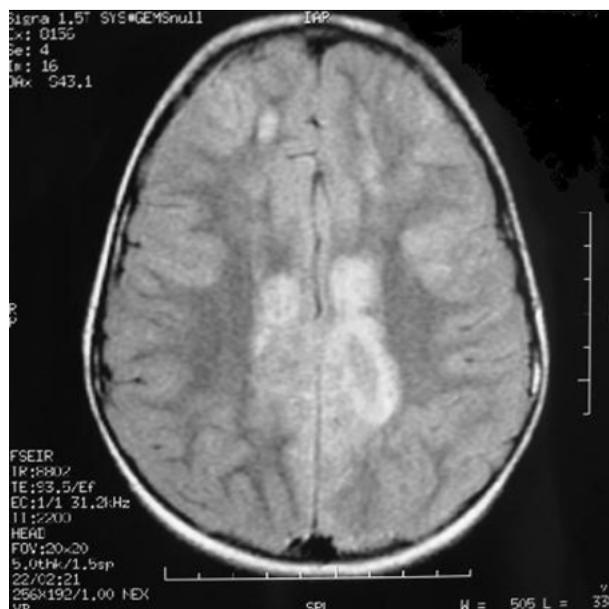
Cranial magnetic resonance image (axial projection) of the case patient, initial presentation, showing multiple areas of T2-weighted and fluid-attenuated inversion recovery signal enhancement, suggesting multifocal demyelination.
